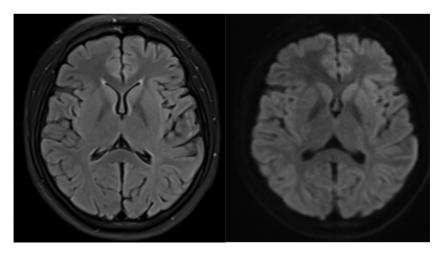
Axial Flair and DWI show Claustrum sign disappeared 3 months later.
